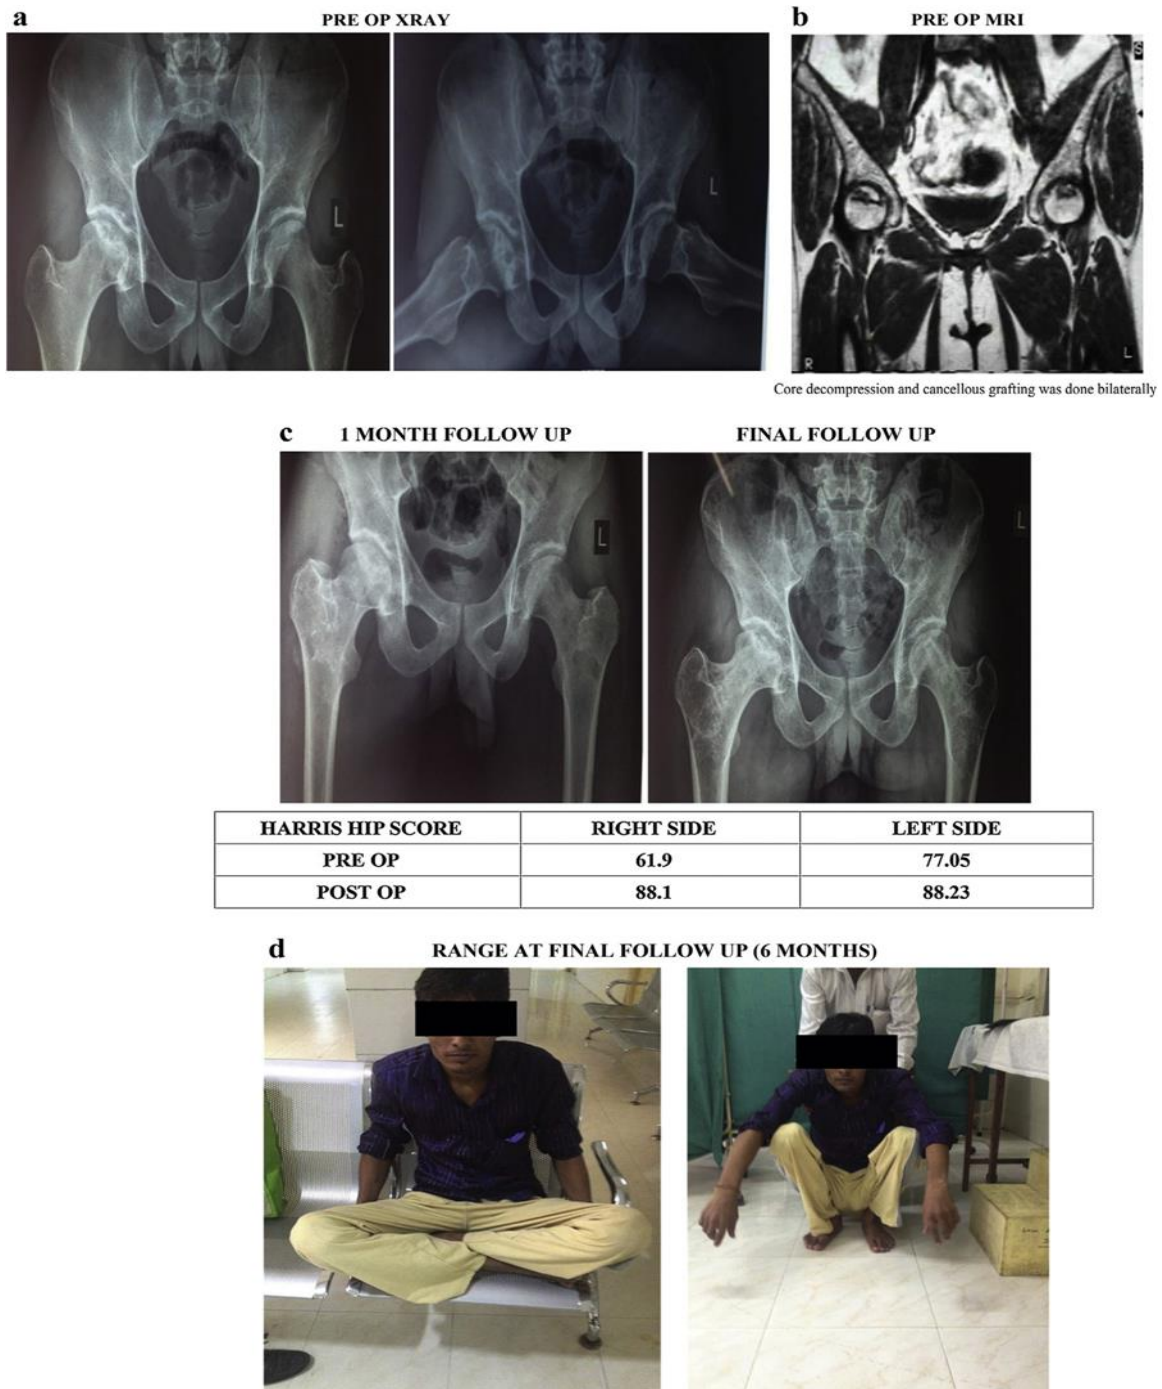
24 yr/M/farmer/pain on Rt hip since 1 year, Lt hip asymptomatic/diagnosed bilateral AVN on MRI (grade IIB on Rt side and grade I on Lt side).
